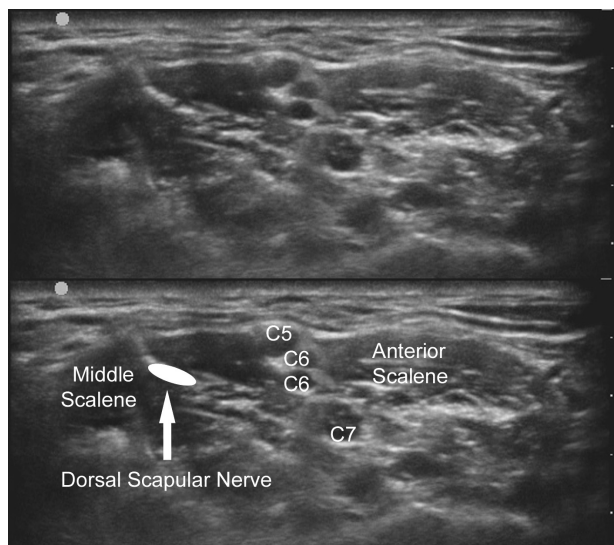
Sonogram showing “classic” interscalene image of the brachial plexus, as well as a dorsal scapular nerve identified in the middle scalene muscle (indicated by large arrow). Right side of the image is medial/anterior.
